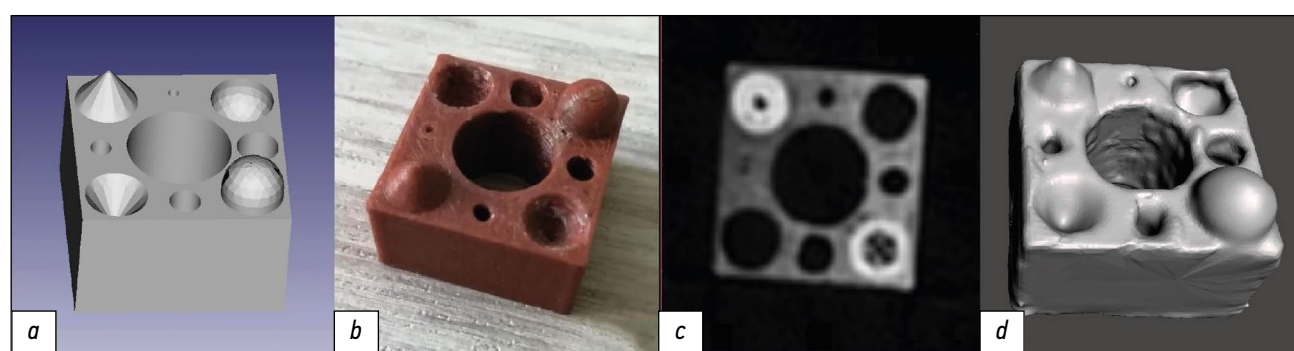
The appearance of the reference model 1 after the following stages: *a*, parametric modeling; *b*, 3D-printing; *c*, CT scanning (axial slice, +805 HU window level, and 3718 HU window width; greater density of protrusions due to closer filament stacking in the horizontal plane), and *d*, creating a polygonal mesh based on CT data. CT: computed tomography.
